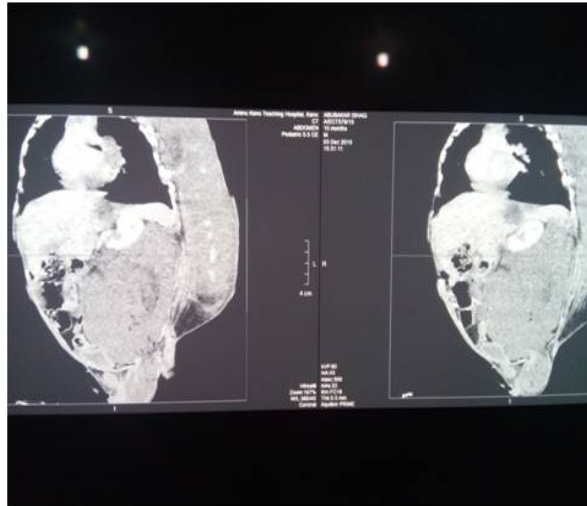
Thoraco abdominal CT
